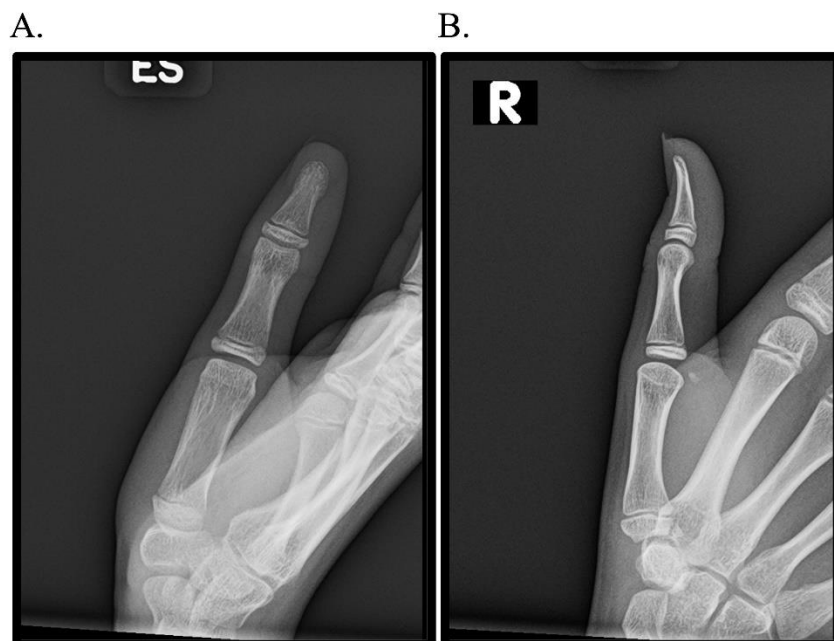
PA (A), lateral (B) radiographs of the right thumb in a skeletally immature individual demonstrating a minimally displaced Bennett-equivalent metacarpal base fracture without associated dislocation or subluxation of the carpometacarpal joint
